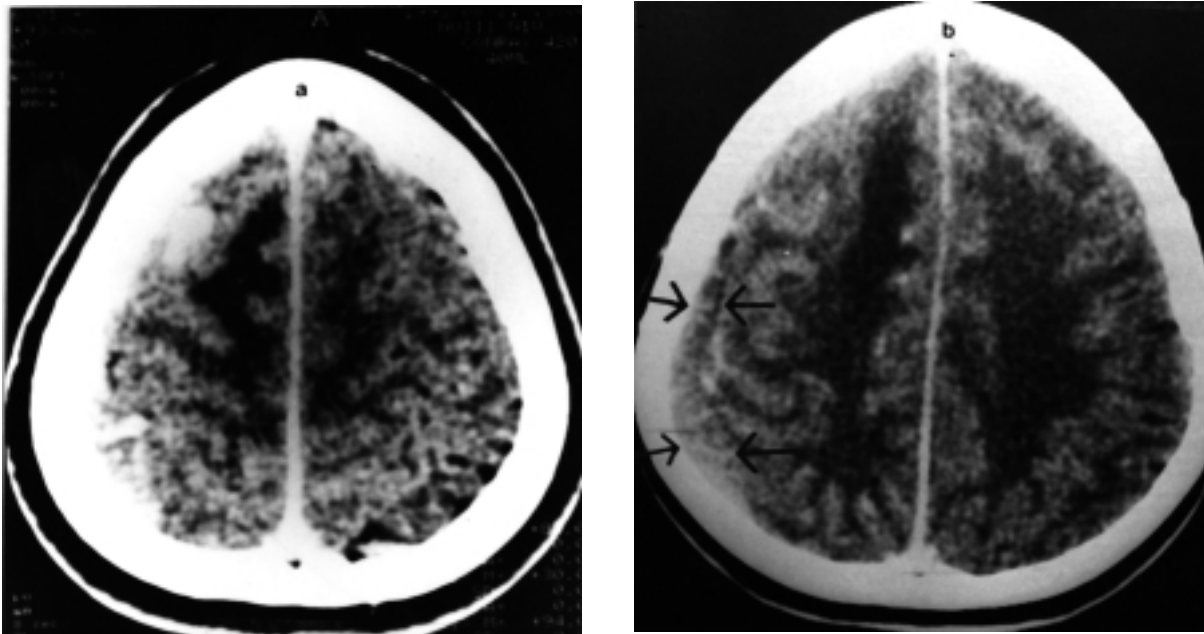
Contrast enhanced CT scan of the brain done a week after onset of symptoms, a) showing lesion in the right posterior frontal region with surrounding oedema, b) additional subdural effusion (arrows).
